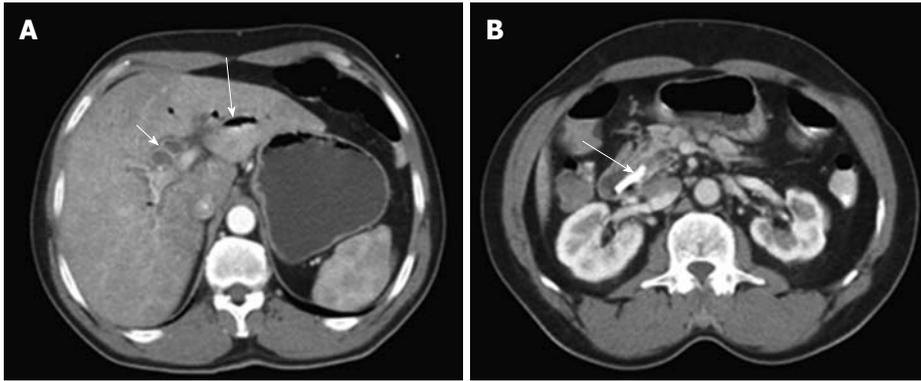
A case of acute cholangitis. A: Computed tomography (CT) scan shows pneumobilia (long arrow), dilated intrahepatic biliary radicles, with enhancing walls (short arrow); B: CT-guided internal drainage stent seen along the common bile duct (arrow).
